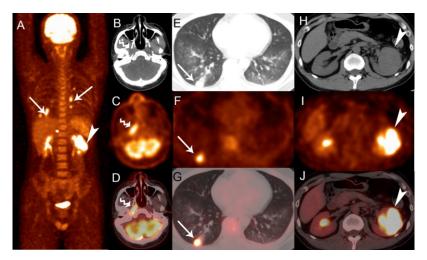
Fluorine-18-FDG PET/CT was subsequently performed for further evaluation. Multiple hypermetabolic lesions were found on maximum intensity projection (MIP) image (A). The axial images of PET, CT, and PET/CT fusion revealed hypermetabolic lesions in the bilateral pulmonary nodules (E, F and G: arrow) and left renal mass (H, I and J: arrowhead) with SUVmax of 7.64 and 13.29 respectively, which were compatible with findings in CT and MRI. Beyond these, there was increased tracer uptake in the right slightly narrowed pharyngeal recess with SUVmax of 6.71 (B, C and D: crooked arrow). In view of imaging features, malignancy especially lymphoma or systemic disease was suspected.
